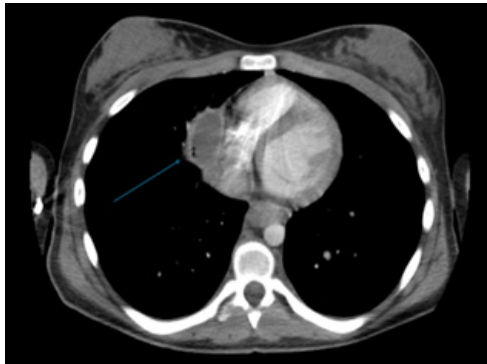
CT chest axial view of the abscess in the right pericardial region.
